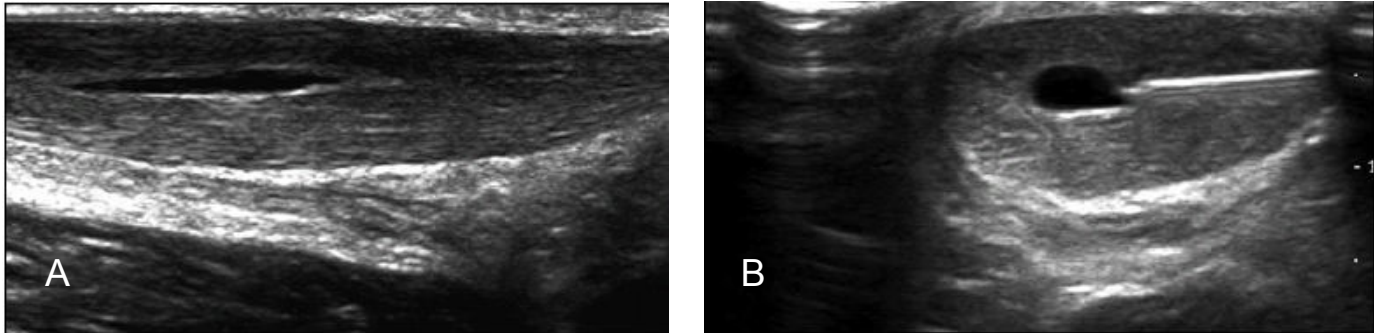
58-year-old woman with midportion Achilles tendinosis. A, Longitudinal sonographic image obtained using 5-12-MHz linear array transducer shows large anechoic cleft in midportion of Achilles tendon. B, Transverse sonographic image of same anechoic cleft after insertion of 27-gauge needle shows tip of needle is located at edge of cleft.
